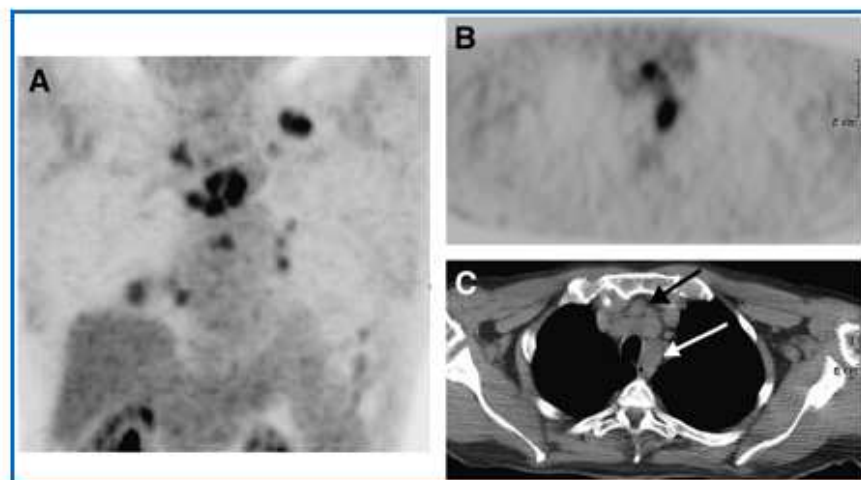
Maximum-intensity-projection (A), transaxial PET (B), and transaxial CT (C) images of 67-y-old man with calcitonin level of 119,000 pg/mL. Maximum-intensity projection shows multiple foci of ^{18}F -FDG uptake in neck, mediastinum, and lungs. ^{18}F -FDG PET and CT show metastatic mediastinal lymph nodes (arrows).
